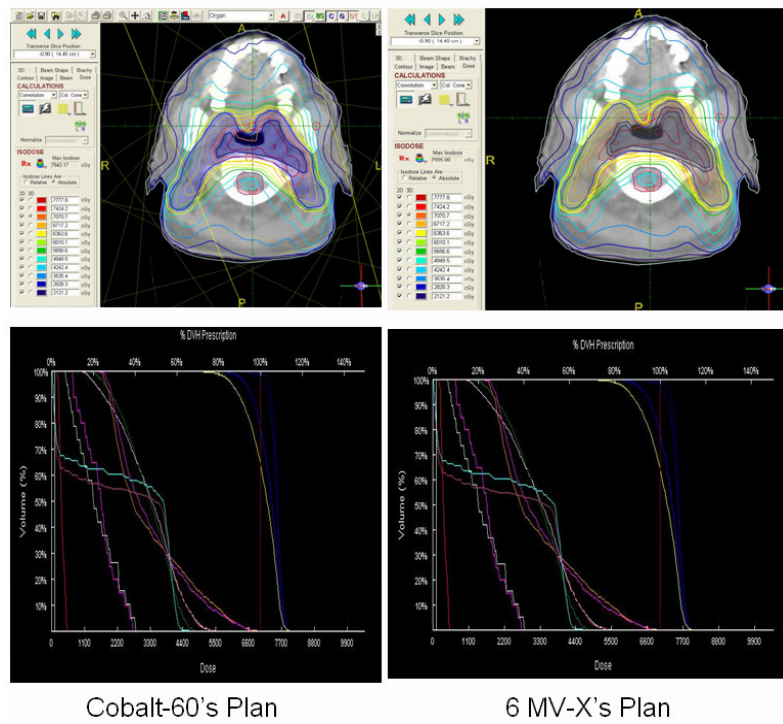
Co-60's plan vs 6MV X-ray's plan for Nasopharynx Cancer (9 Beam's IMRT plan).
